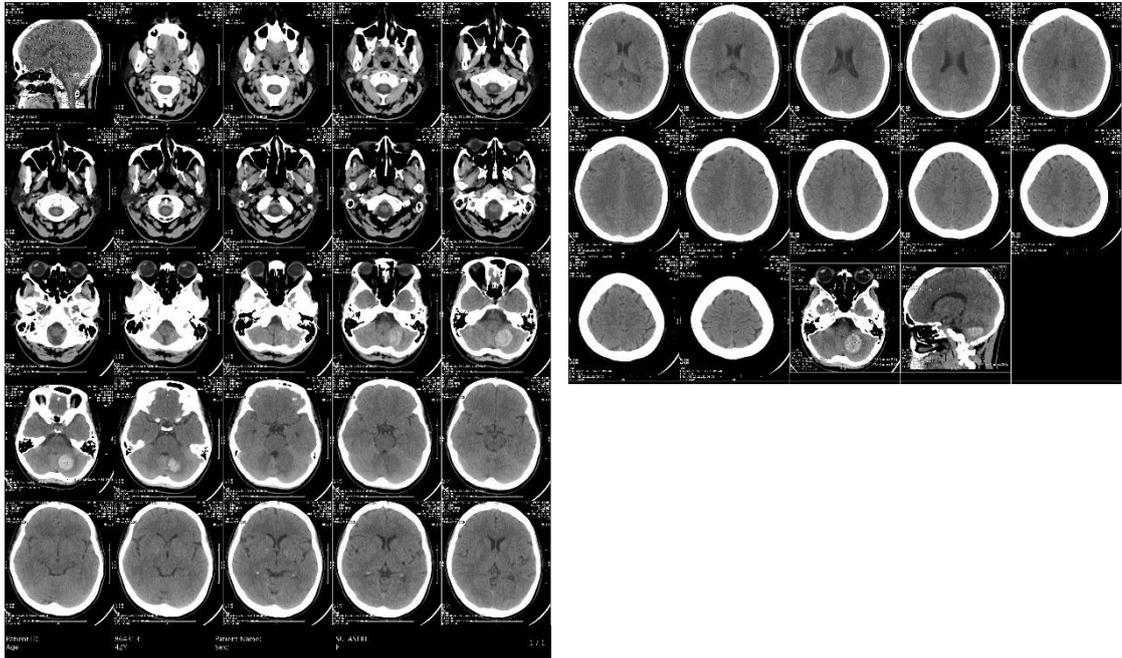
non-contrast head CT scan showed ICH in the left cerebellum
